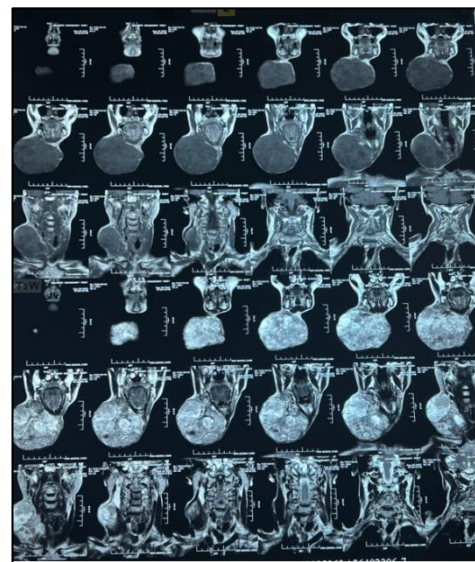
MRI T1W of neck-coronal section depicting right submandibular gland lesion.
